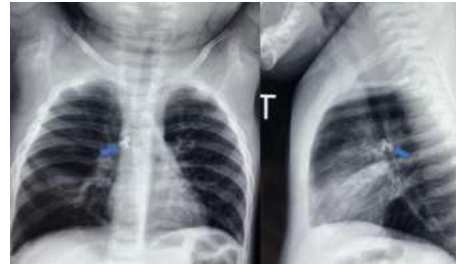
Chest X-ray PA and lateral views showing radio-opaque foreign body (screw) in the right main bronchus.
